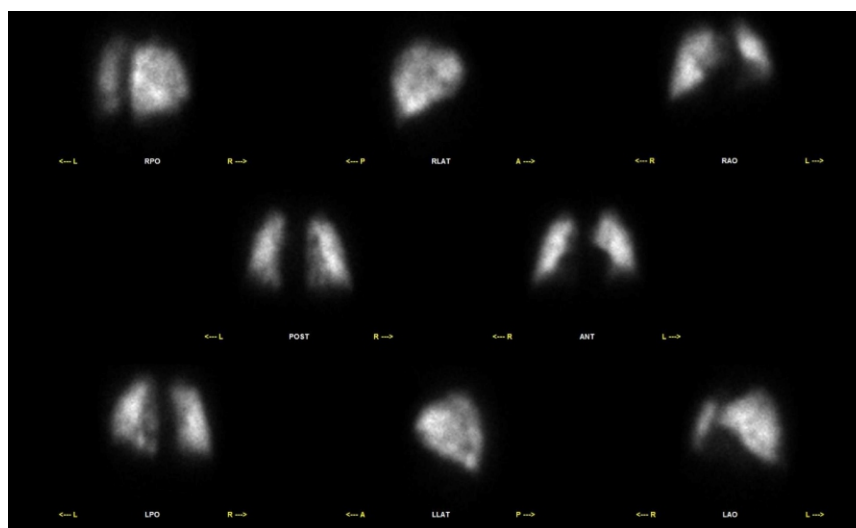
A LPS of a female of 68 years old, with dyspnea, cough and DVP as a risk factor. The value of D-dimer was 2014 μ g/L (n.v. <500) and chest CT showed signs of inflammatory interstitial disease. Irregular uptake was detected in both lungs due to chronic parenchymal disease, negative for APE.
